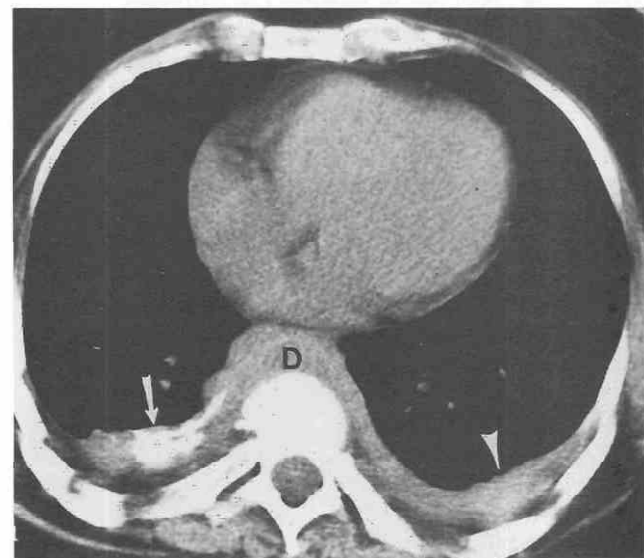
Posterior mediastinal fibrosis. CT shows diffuse soft-tissue-attenuation mass encasing the distal aorta (D) and extending into the pleural space (arrowhead) bilaterally. Extensive calcification (arrow) can be visualized in the right pleural space.
